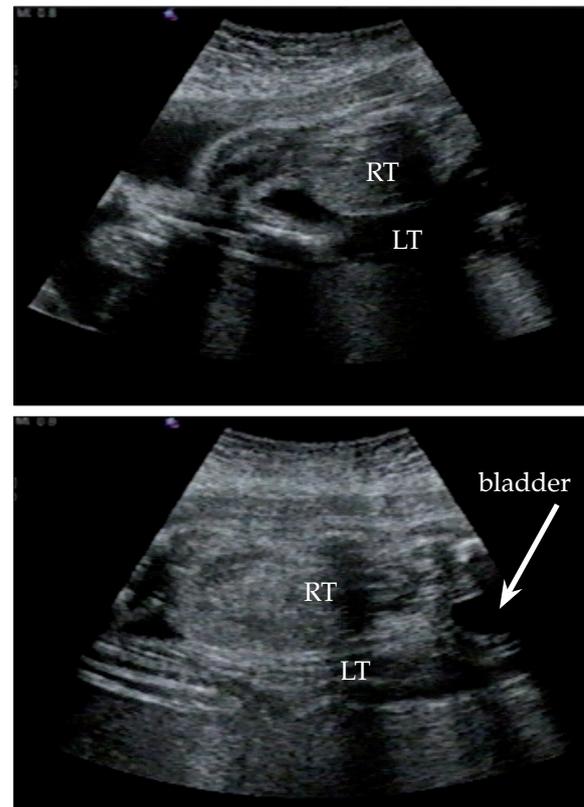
Sonographic images of the fetal thigh at 30 weeks' (left image) and 36 weeks' gestation (right image) demonstrating the soft-tissue swelling in the medical aspect (RT = right thigh; LT = left thigh).
